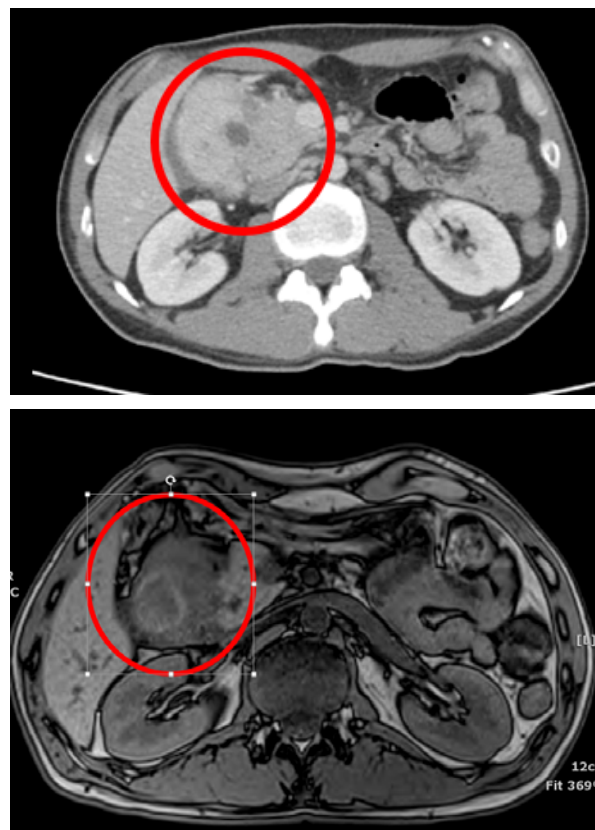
Contrast enhanced abdominal computed tomography (CT) and magnetic resonance cholangiopancreatography (MRCP) of the abdomen demonstrating concentric wall thickening over the proximal duodenum (red circles).
